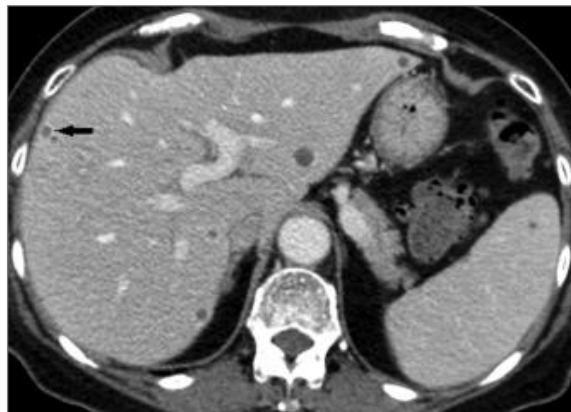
CT scan with multiple hypodense *Candida* micro abscesses in the liver and spleen. The arrow indicates peripheral contrast uptake of the small abscess (Cornely, Bangard and Jaspers, 2015).
